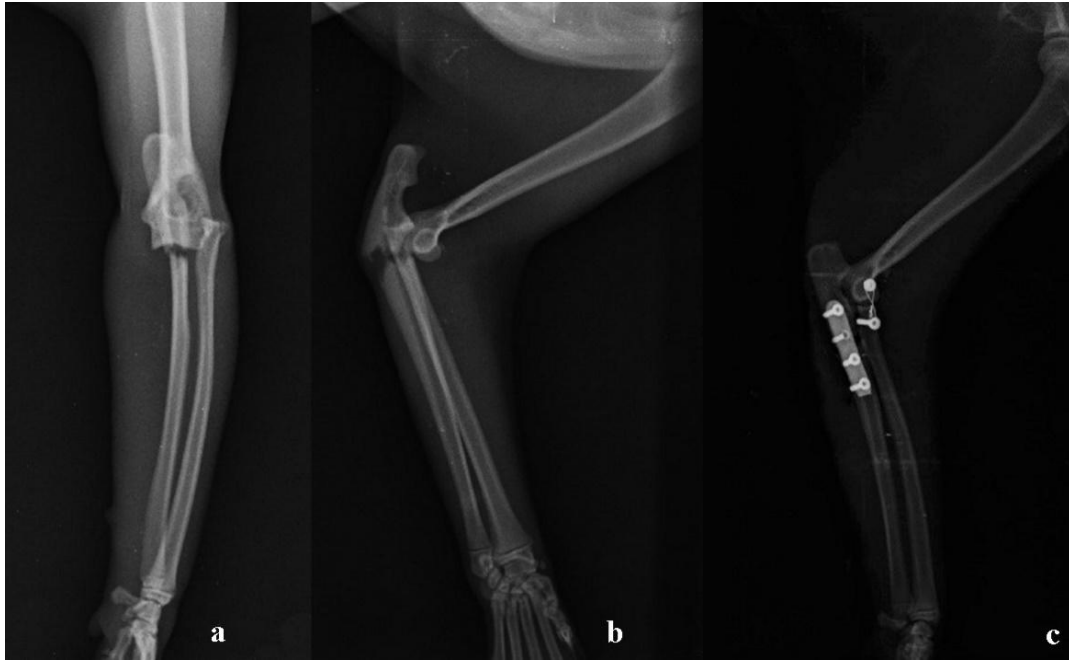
Case no 18 radiographs: a and b. preoperative, c. postoperative day 21
